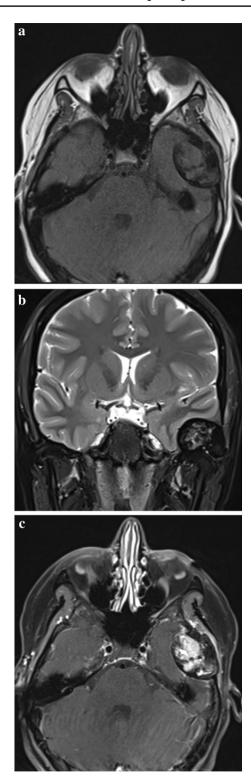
MRI. a Axial T1-weighted image showing the expansion of the temporal bone with strong peripheral hypointensity. b Coronal T2-weighted image showing peripheral hypointensity with some central patchy hyperintense areas. c Axial post contrast T1-weighted image: intense and heterogeneous enhancement
